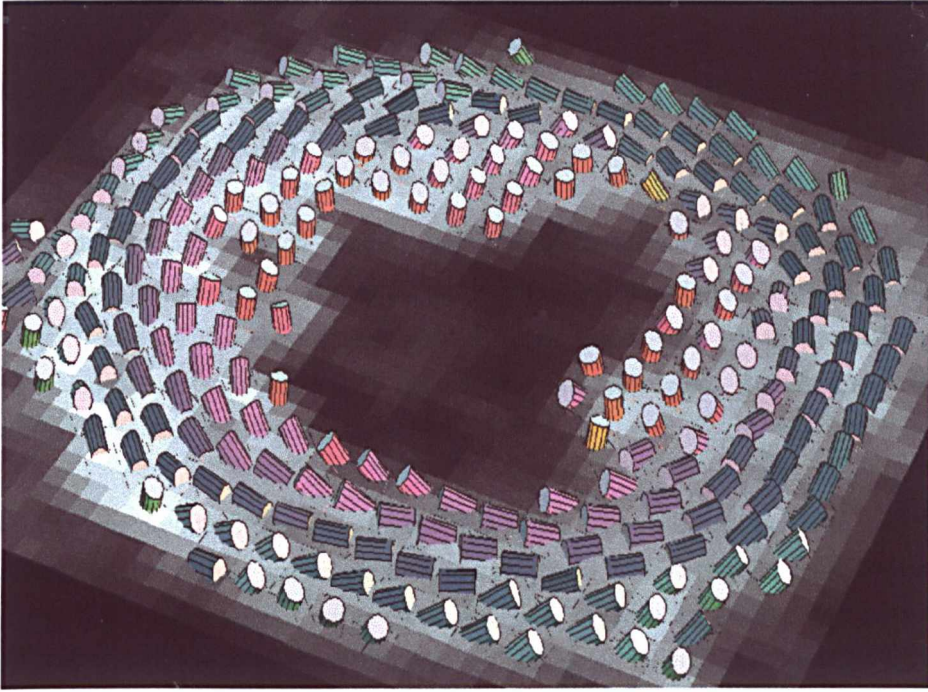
Diffusion tensor MRI of the myocardial fibre orientation in the beating heart. 3D fibre orientation is represented at each pixel by a cylinder pointing along the first eigenvector of the diffusion tensor, and colour-coded according to the fibre helix angle¹²⁰. [Image courtesy of Prof Van J Wedeen, NMR Centre and Department of Radiology, Massachusetts General Hospital and Harvard Medical School, USA]
